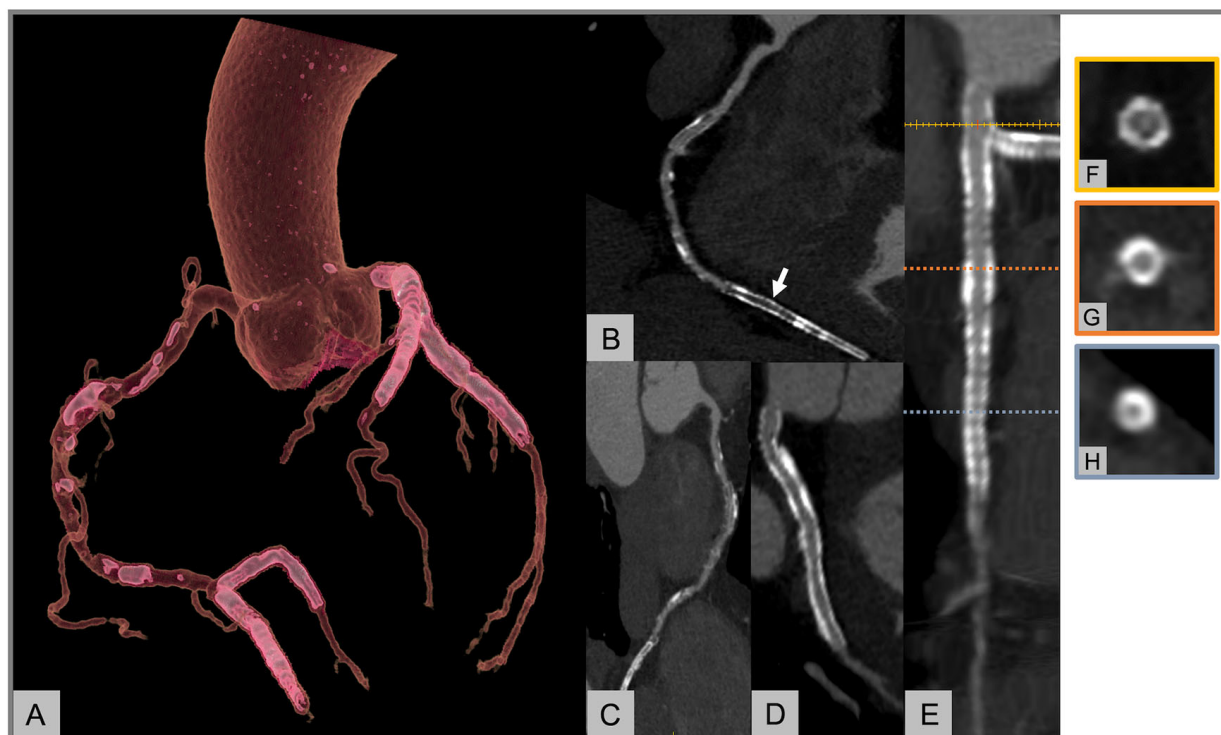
CCTA in patients with multiple coronary stents. (A) A 58-year-old man underwent CCTA due to recent onset of atypical chest pain. The patient had prior multiple stenting as shown in the volume rendering reconstruction of the coronary tree. (B–D) Curved MPRs of RCA-PDA (B), RCA-PL (C) and LCX (D). The stent lumen on the PDA artery (B, arrow) appears homogeneously hypodense indicating stent occlusion. (E–H) Straight MPR of LM-LAD (E) and cross-sectional images of distal LM (F) as well as proximal (G) and distal (H) LAD. CCTA demonstrated a dark rim in the distal LM stent documenting the presence of in-stent restenosis (F). While the stent in the proximal LAD (G) was assessable and judged as patent, the small size of the stent in the distal LAD (H) precluded the evaluation of the lumen. CCTA, coronary computed tomography angiography; LAD, left anterior descending Artery; LCX, left circumflex artery; LM, left main; MPR, multiplanar reconstruction; PDA, posterior descending artery; PL, posterolateral branch; RCA, right coronary artery.
